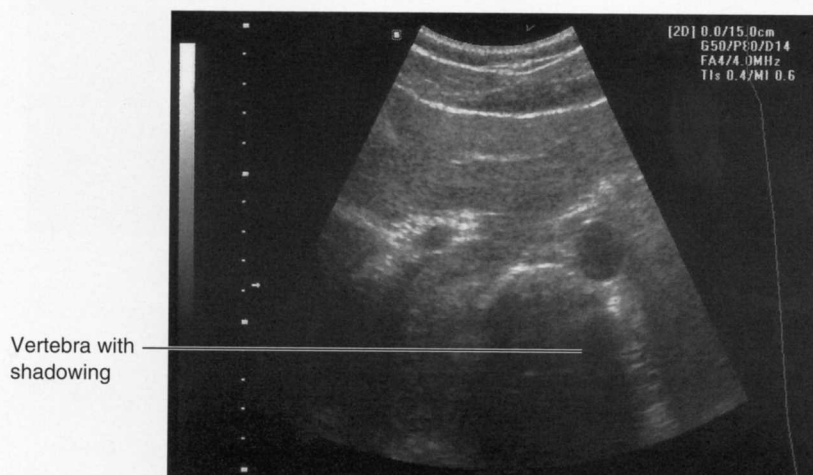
Sonographic appearance of a vertebral body in the transverse orientation. Note the echogenic proximal surface and the distal attenuation shadow of the vertebra.
